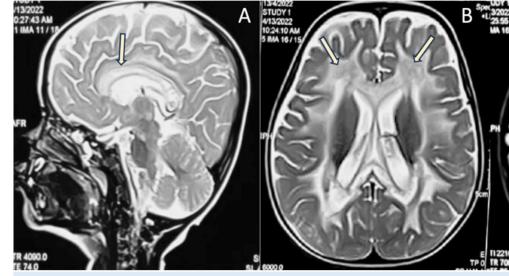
MRI brain T2 sagittal section shows hyperintensity in corpus callosum hyperintensity (arrow in A). T2 and FLAIR axial section show hyperintensity and cavitations in bilateral diffuse , periventricular and subcortical white matter (arrows in B and D). DWI shows diffusion restriction in corresponding white matter(arrows in D). (Mitochondrial Leukodystrophy pattern)
